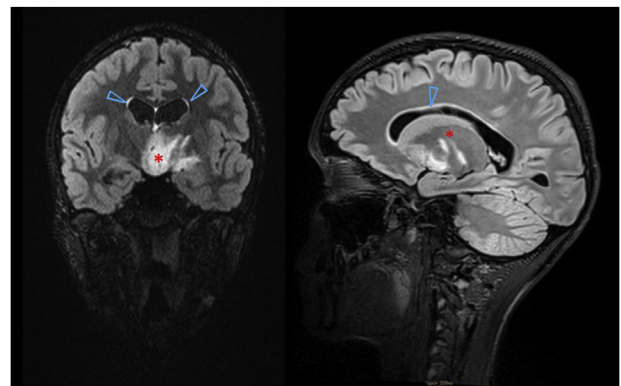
T2-weighted FLAIR images (coronal and sagittal planes, respectively) showing a poorly defined hypothalamic lesion with obstruction of the third ventricle (*) and moderate prominence of lateral ventricles with mild transependymal edema (Δ).
